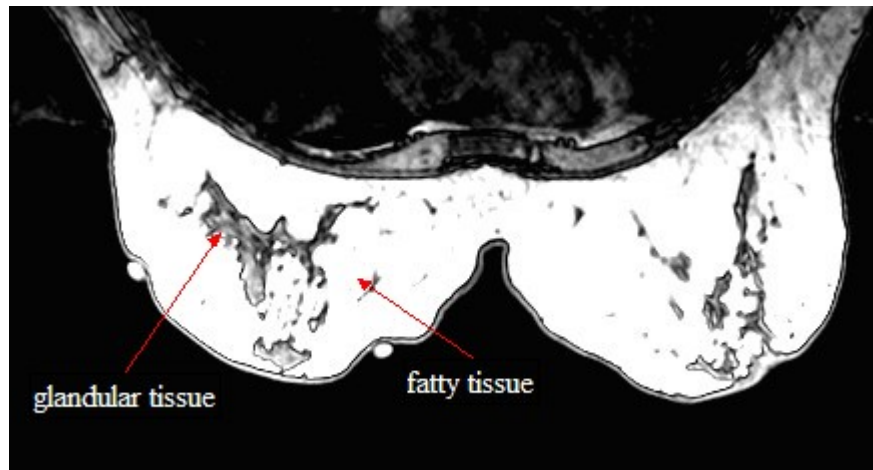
Axial MRI image through middle of breast with contrast adjusted using a linear window to maximize detail of the glandular tissue.
